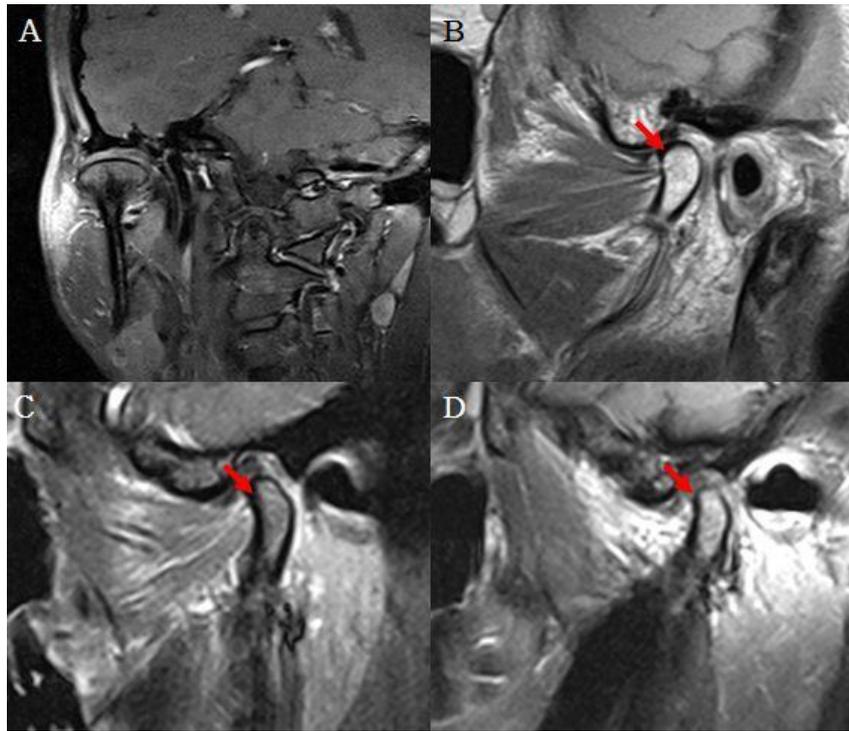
MRI findings of condyle degeneration. MRI findings show degree of condylar degeneration. (A: Normal relationship between condyle and disc., B: Degeneration of condyle, beginning, C: Degeneration of condyle, intermediate state, D: Significant degeneration of condyle and disc)
